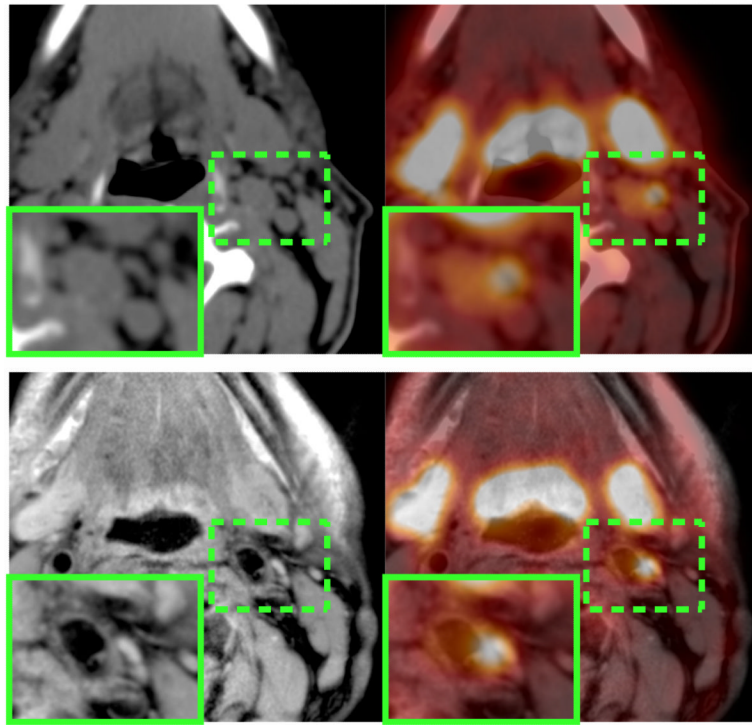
PET/CT (top row) vs. PET/MR (bottom row) of a patient with an inflamed plaque. Higher soft-tissue contrast of the MR image (bottom left) compared to the CT image (top left) allows better delineation of the luminal area and therefore improves quantification of the PET uptake signal.
